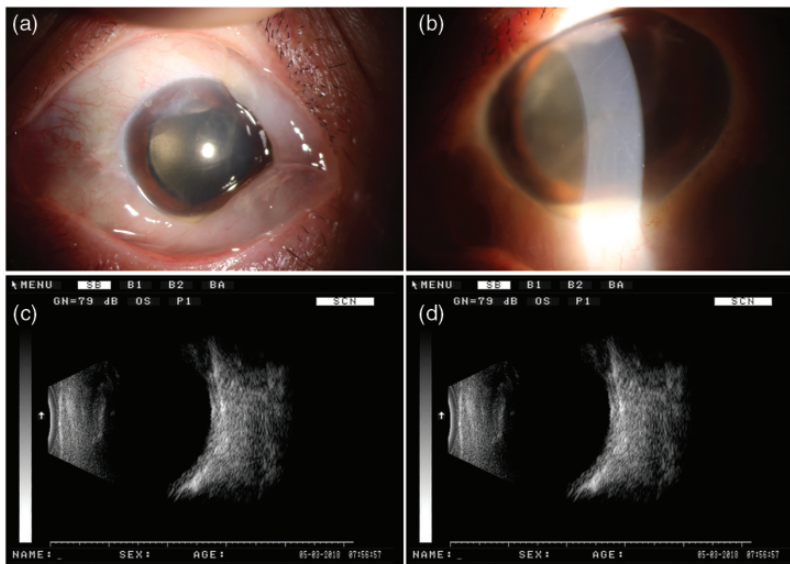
Preoperative images of anterior segment and B-ultrasound examination. (a, b) Clinical images of anterior segment showing corneal endothelial folds, dusty keratic precipitate, and hypopyon. (c, d) B ultrasound images showing clear vitreous.
